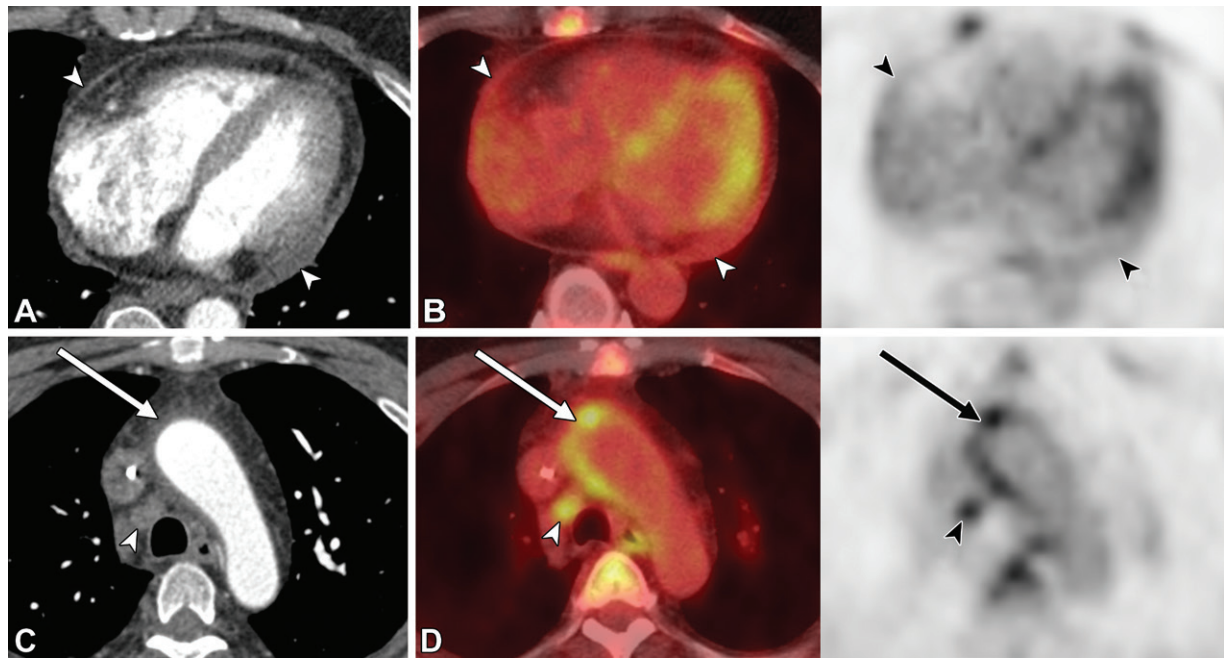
Chemotherapy-associated acute pericarditis in a 63-year-old woman with small cell carcinoma of the lung. After completion of cycle 3 of carboplatin-etoposide chemotherapy, the patient developed fevers and pleuritic chest pain. (A, C) Transaxial contrast-enhanced CT images show new mild pericardial thickening with trace pericardial fluid and mild adjacent fat stranding (arrowheads in A), including involvement of the superior aortic recess (arrow in C). (B, D) Transaxial fused FDG PET/CT (left) and PET (right) images show corresponding increased mild linear uptake along the right atrium and base of the left ventricle (arrowheads in B), as well as more avid uptake along the superior aortic recess (arrows in D), raising suspicion for acute pericarditis. The extent of increased activity along the ascending aorta is limited to the area of the superior aortic recess without circumferential aortic involvement, favoring acute pericarditis rather than aortitis. Although more focal uptake is seen in the superior aortic recess, no soft-tissue nodularity is seen at dedicated CT of the chest to suggest metastasis, and these findings had resolved at short-interval follow-up. Arrowheads in C and D denote an adjacent hypermetabolic right paratracheal nodal metastasis.
